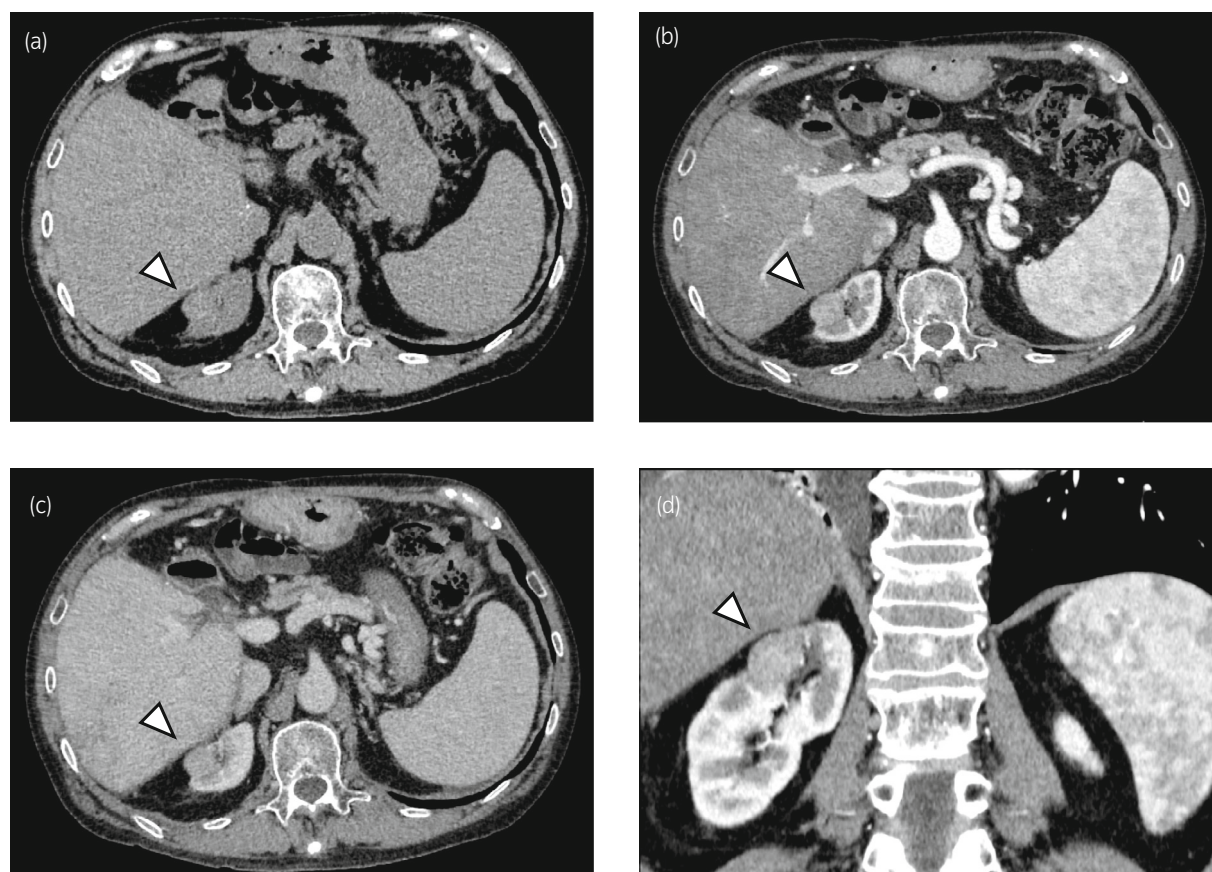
Computed tomography (CT) images of the right kidney tumor (a: plain CT; b and d: arterial phase; c: venous phase). A 24 × 23-mm mass with arterial phase enhancement and venous phase washout (arrowheads) was detected in the upper pole of the right kidney.
